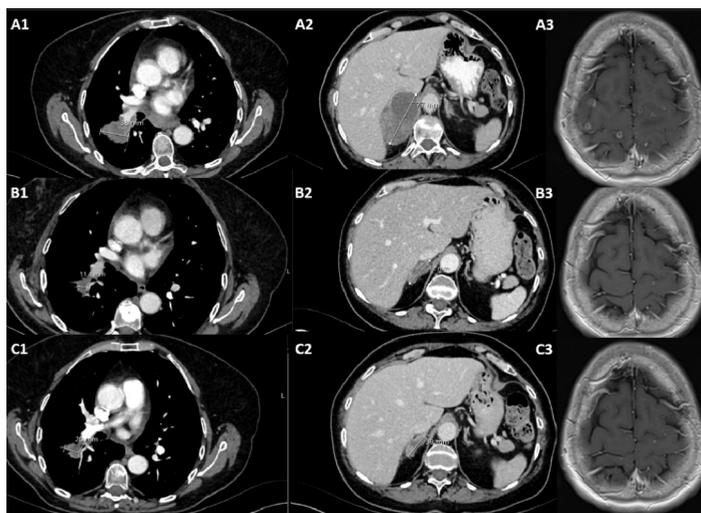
Thorax and abdominal computed tomography revealing partial response, and similar findings obtained in the follow-up.
